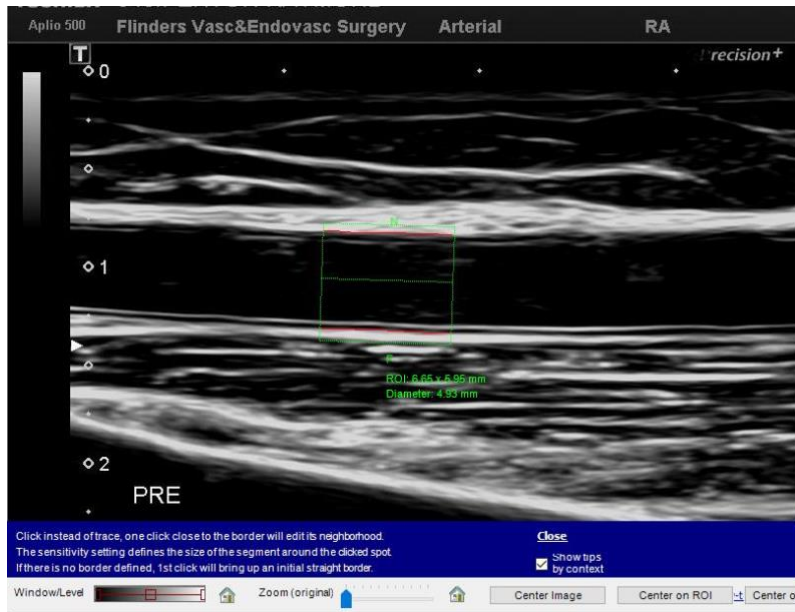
Brachial Artery Ultrasounds with FMD analysis software ROI
